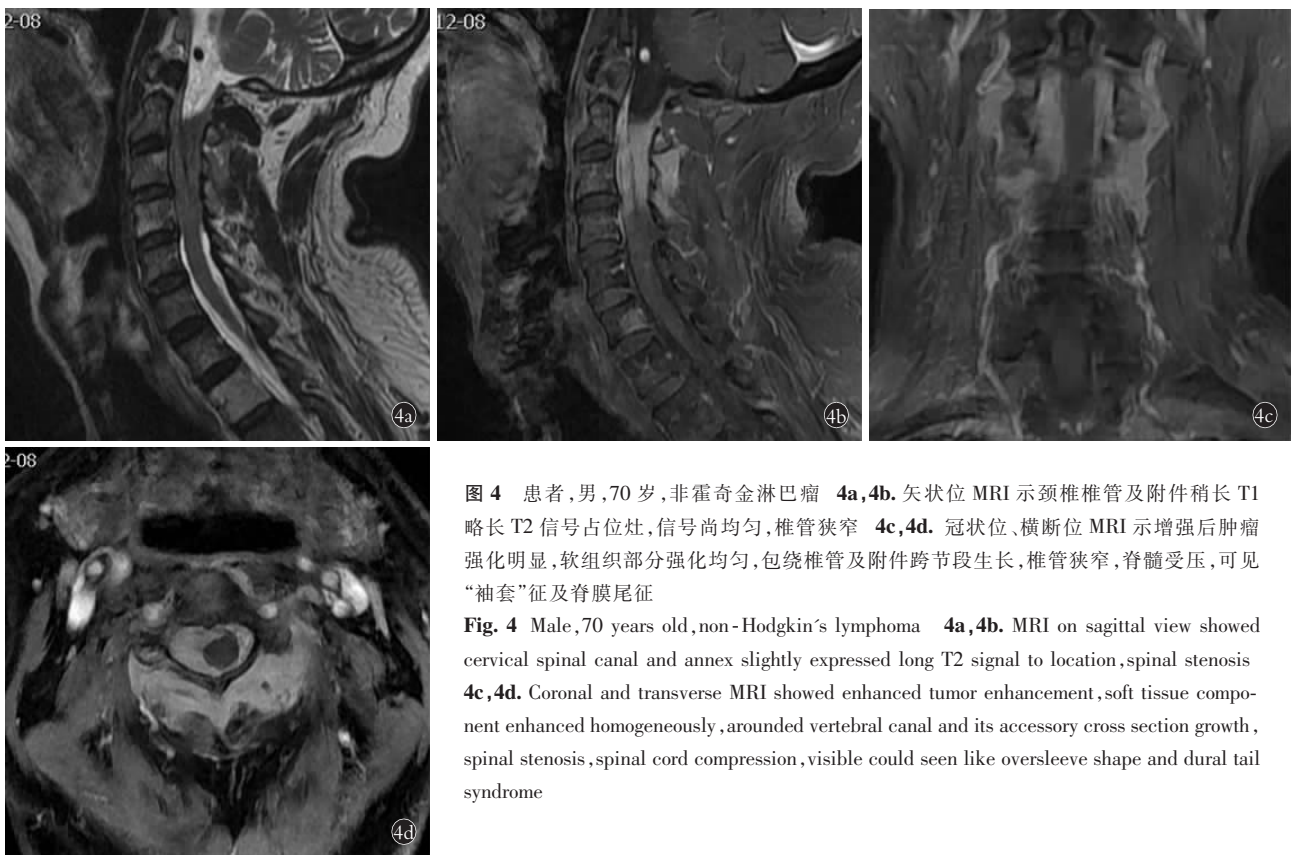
患者,男,70 岁,非霍奇金淋巴瘤 4a,4b. 矢状位 MRI 示颈椎椎管及附件稍长 T1 略长 T2 信号占位灶,信号尚均匀,椎管狭窄 4c,4d. 冠状位、横断位 MRI 示增强后肿瘤强化明显,软组织部分强化均匀,包绕椎管及附件跨节段生长,椎管狭窄,脊髓受压,可见“袖套”征及脊膜尾征
